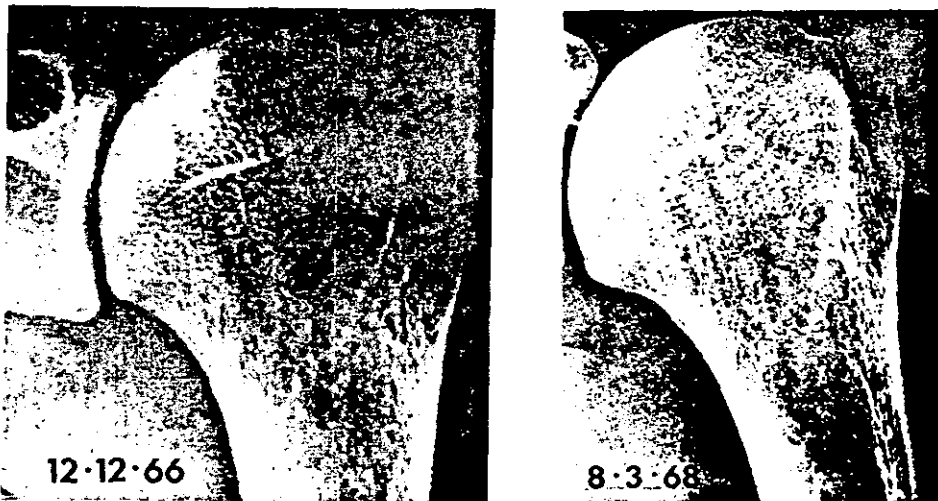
(Left) Same case as Fig. 4.36 almost 4 years after the original radiograph. Well-defined dense areas in the head of the humerus.
